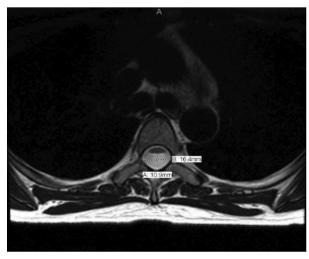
MRI of the thoracic spine depicting a T2 hyperintensity posterior to the cord around the arachnoid space between T4-T9 representing a likely arachnoid web with some associated cord flattening (sagittal view on the top, axial view at the bottom). MRI, magnetic resonance imaging.
